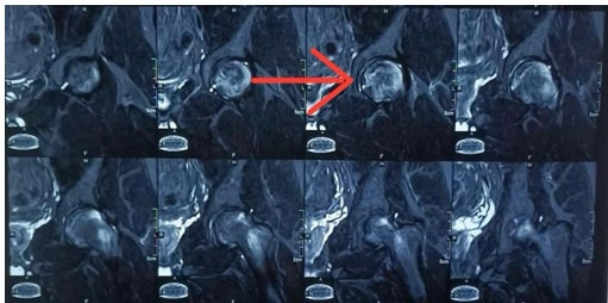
MRI-Pre-operative left hip.
